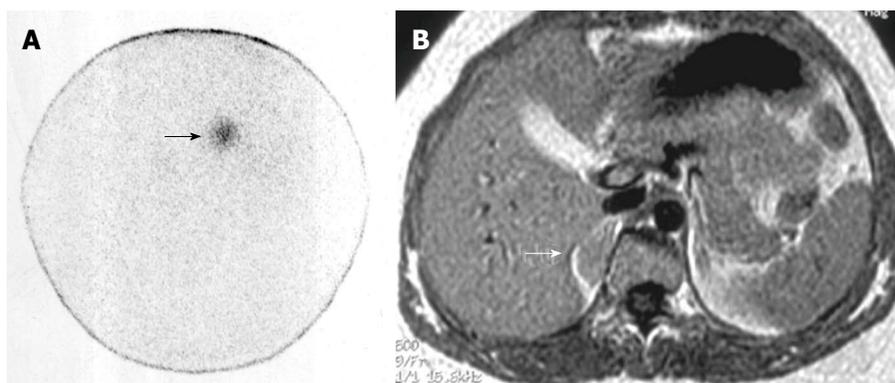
Right non-hypersecreting adrenal adenoma. A: Abdominal posterior scan of I-131 nor-cholesterol scintigraphy demonstrates abnormal (faint) focal uptake in the right adrenal (black arrow) where a mass was detected by magnetic resonance (MR); no detectable tracer uptake in the left adrenal bed; B: T1-weighted axial MR detects a small lesion in the right adrenal bed (white arrow) isointense compared to liver signal intensity.
